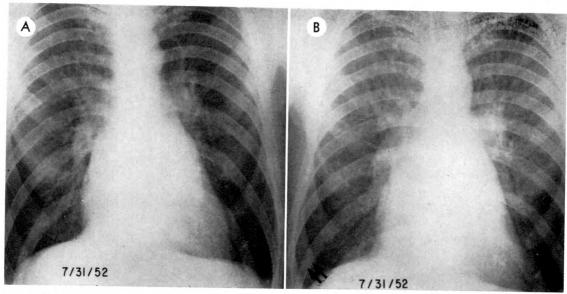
Male with known mitral stenosis. (A) Posteroanterior chest roentgenogram demonstrates an enlarged left atrium with distention of upper lobe veins and contraction of lower lobe veins. (B) This patient was exercised and roentgen findings of interstitial pulmonary edema in the form of A-lines (A) and B-lines (A) are noted on the roentgenogram made immediately after exercise. In addition, there is greater distention of upper lobe veins. Comment. This case demonstrates graphically that A-lines and B-lines may develop in an extremely brief period of time as a manifestation of interstitial pulmonary edema. Such changes are apparently secondary to a rise in the pulmonary venous pressure to greater than 25 mm. of mercury. In this patient, the elevated venous pressure is graphically demonstrated by the distention of the upper lobe veins and the contraction of the lower lobe veins. Often, however, the abnormalities of veins are difficult to appreciate and when there is a rise in postcapillary pulmonary resistance, this frequently may be diagnosed roentgenographically with greater certainty from the findings indicative of interstitial pulmonary edema.
